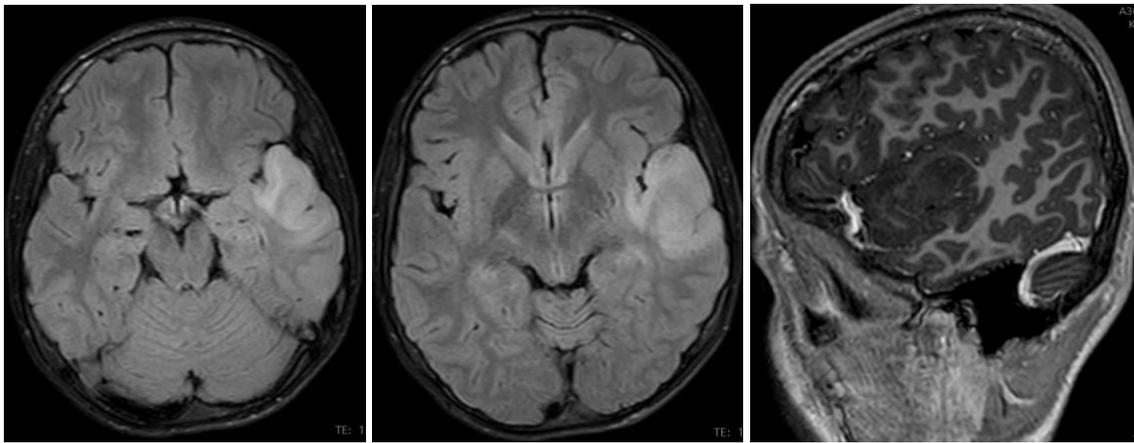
MRI revealed a non-enhancing T2-hyperintense lesion in the left superior and middle temporal gyri with radiologic appearance of LGG
